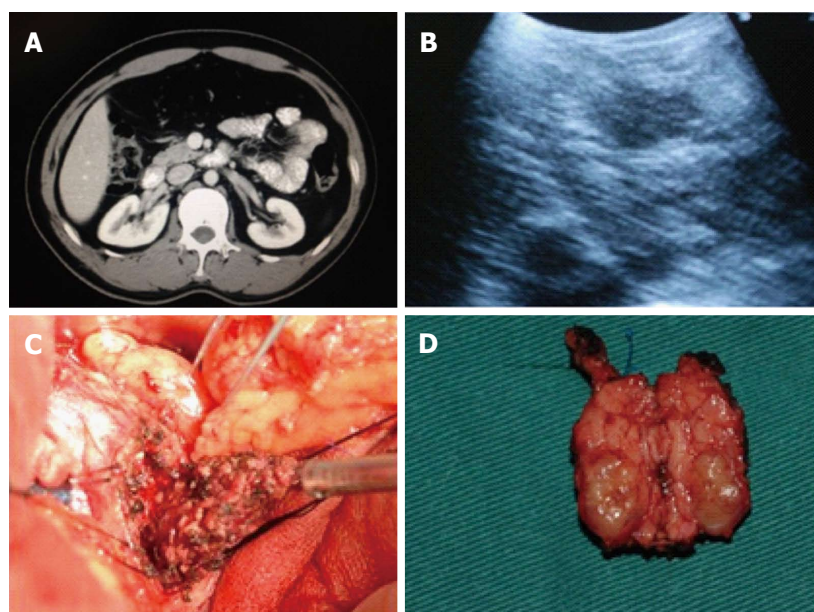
B-ultrasonic examination and computed tomography scan of case 3. A: Enhanced computed tomography image of BTPH shows oval solid lesions measuring 3.3 cm in diameter in the uncinate process. BTPH had significantly strengthened density around the enhanced loci; B: The uncinate process carcinoma of the pancreas is solid texture with low density in area of 3.6 cm × 3.5 cm; C: The uncinate process carcinoma of pancreas is a solid mass with uneven texture in area of 3.2 cm × 3.5 cm; D: Pancreaticojejunostomy Roux-en-Y anastomosis shows wound surface area measuring 5.2 cm × 5.0 cm. BTPH: Benign tumors of the pancreatic head.
